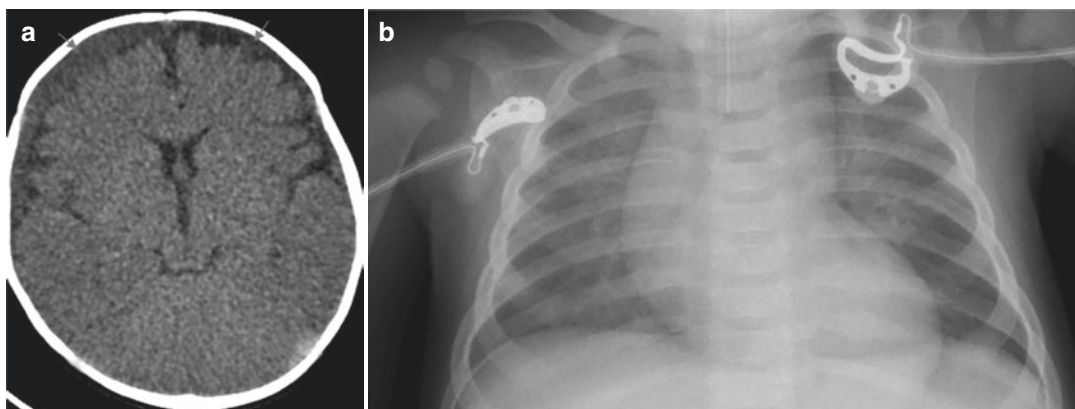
(a) Axial CT scan of the brain demonstrating bilateral subdural collections of mixed attenuation. (b) Chest X-ray of the same case revealed healing rib fractures of the posterior aspect of the left eighth and ninth ribs
